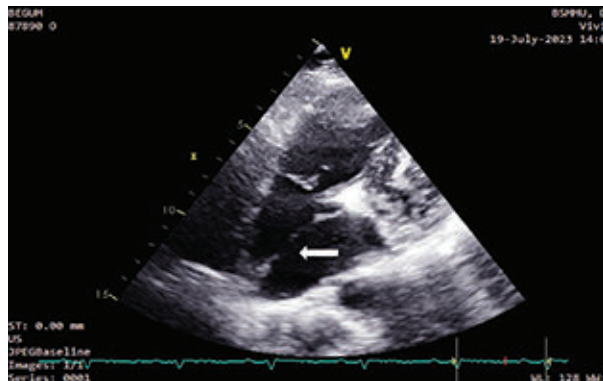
Parasternal short axis view shows dilated RV.
